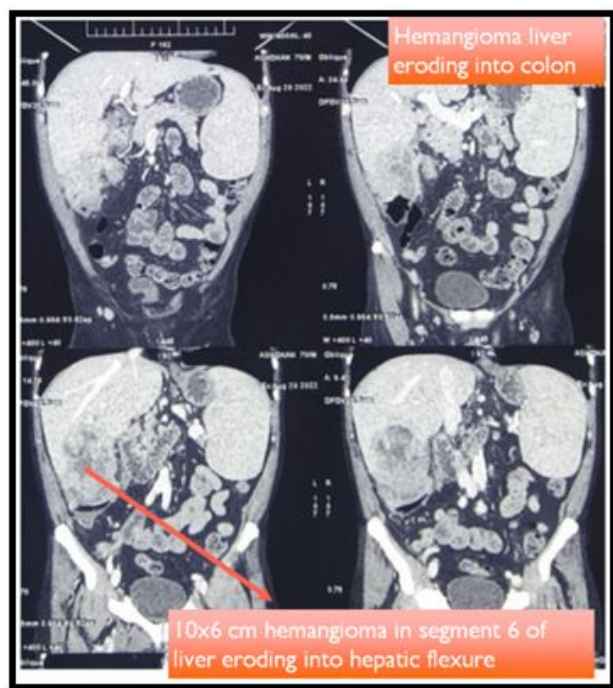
TRIPLE PHASE CT ABDOMEN-HEMANGIOMA IN SEGMENT 6 OF LIVER ERODING INTO ASCENDING COLON AND HEPATIC FLEXURE
